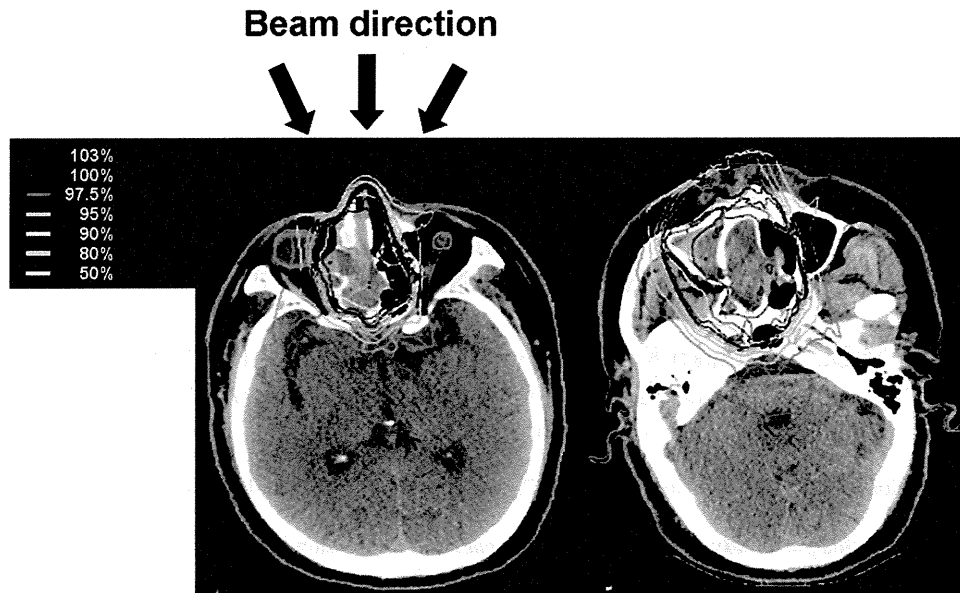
Target volume and beam arrangement. GTV was defined as the gross tumor lesion determined with pretreatment CT/MRI and PET. CTV was defined as the region of the gross tumor lesion and adjacent sinuses. PTV was basically set as CTV plus 3-mm margin, with acceptance of fine-tuning to the PTV in consideration of organs at risk. Irradiation dose and volume for organs at risk were usually minimized by using a noncoplanar three-field technique.
